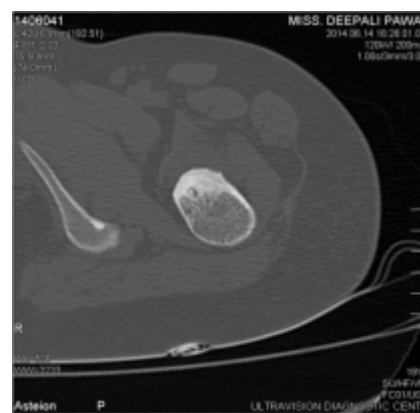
Plain CT Sclerotic Lesion with Hypodense Nidus in Intertrochanteric Region
